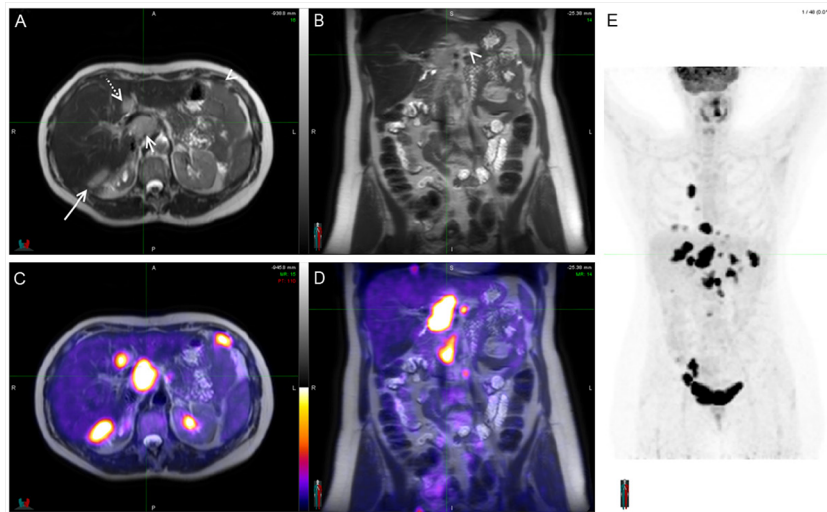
PET/MRI: An emerging hybrid imaging technique.
